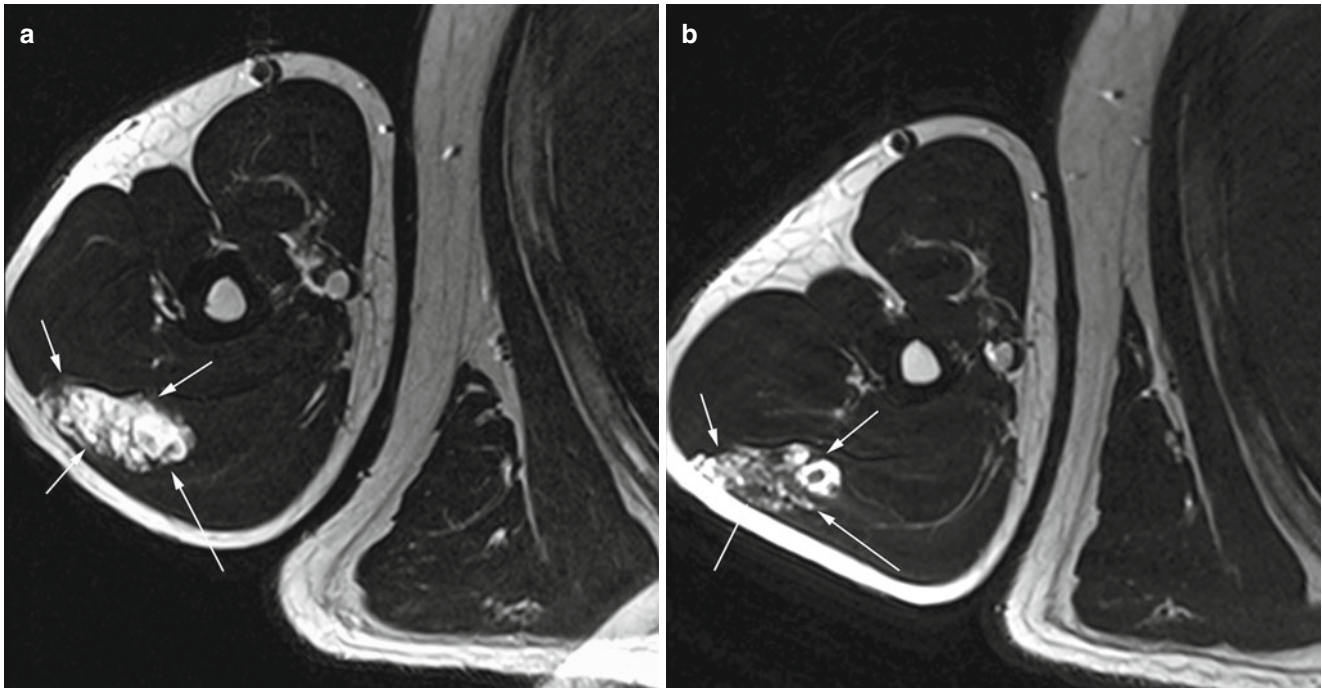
(a, b) Transverse T2-weighted MR images of venous malformation (*arrows*) in the right triceps muscle, (a) before, (b) after sclerotherapy with polidocanol. Note marked reduction of hyperintense
